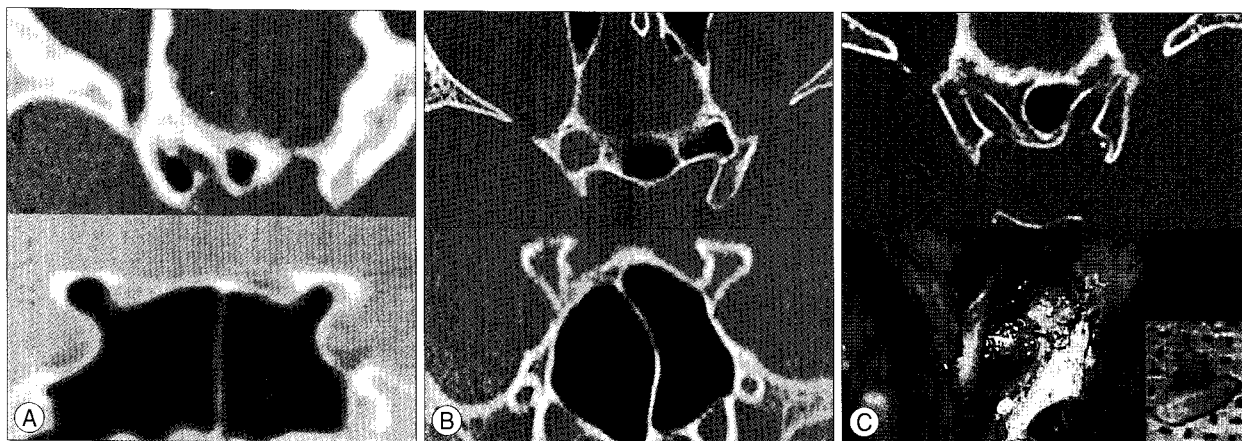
Preoperative evaluation of the temporal bone by computed tomography (CT). A : Pneumatizations of the anterior clinoid process (ACP) and optical strut - type I²⁸⁾. B : Well developed ethmoid sinus. C : Erosive compression of the ACP in preoperative temporal bone CT and surgical findings.
